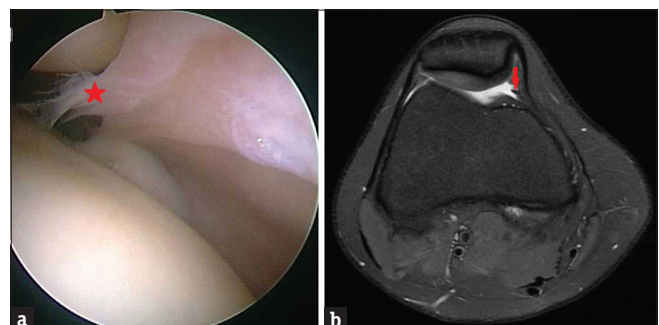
(a) Medial patellar plica (Sakakibara type A) in a 20-year-old young adult male. Axial fat-sat spin-echo proton density (3000/50) magnetic resonance image demonstrating a thin, hypointense line (arrow) originating from the medial wall of the right knee joint. (b) Diagnosis of mediopatellar plica (star) on arthroscopy demonstrating plica reaching the joint space, exfoliates, or an indentation like wear
